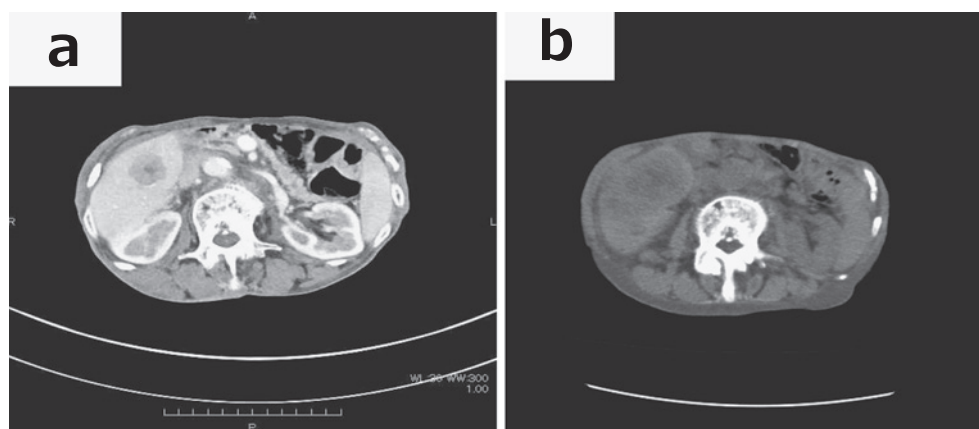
Computed tomography (CT) images show liver metastases before chemotherapy (a) and after chemotherapy (b).
